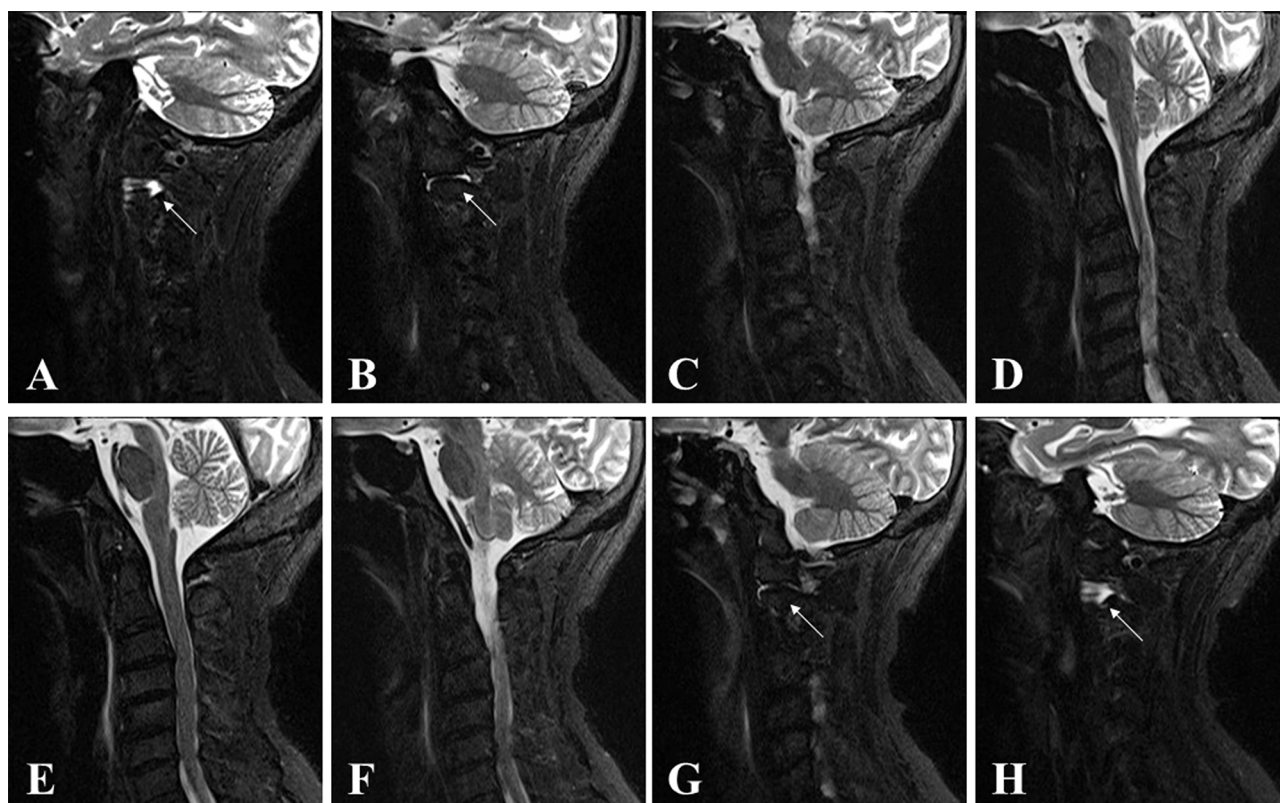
Sagittal T2-weighted MR imaging with fat suppression reveals a non-invasive, mass-like lesion around the odontoid process, but the soft tissue surrounding the dense is hyperintense (white arrow) (A–H; from the right side to the left side).
